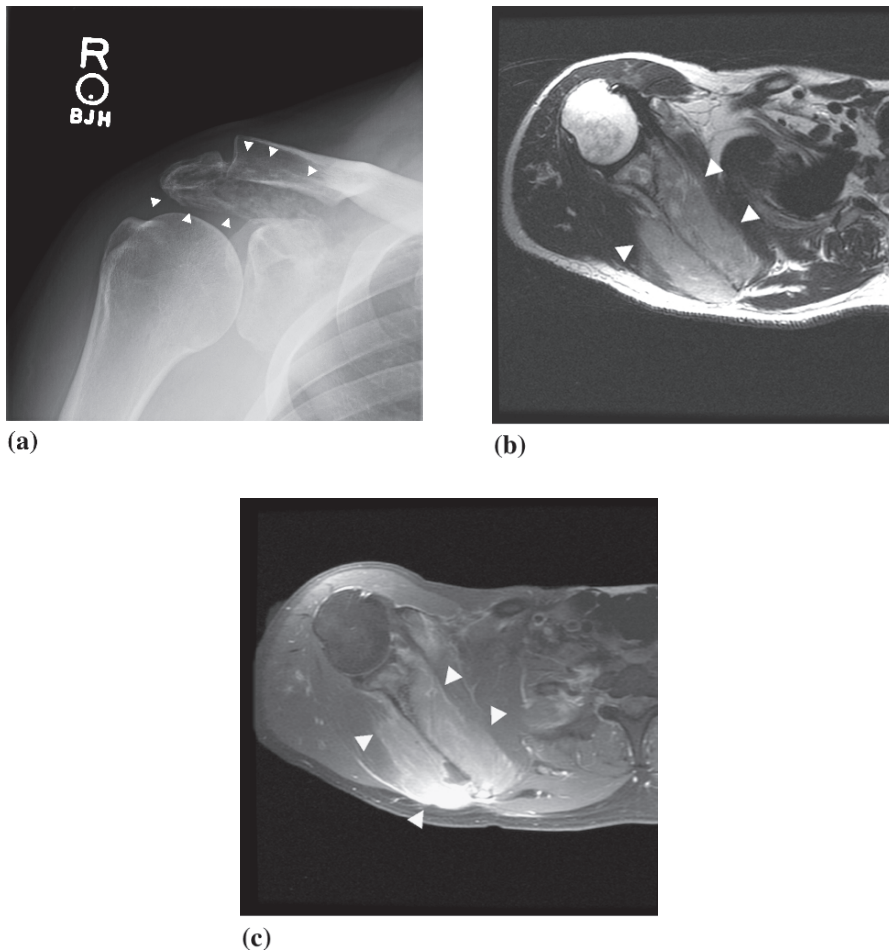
Lymphoma in a 36-year-old male. (a) Radiograph shows a permeative lesion involving the acromion and extending into the scapular body (arrowheads). (b) Axial T2 and (c) axial T1 post-gadolinium fat saturation MR images of the scapular body reveal a large soft tissue mass centered at the scapular body (arrowheads) that displaces the rotator cuff musculature
